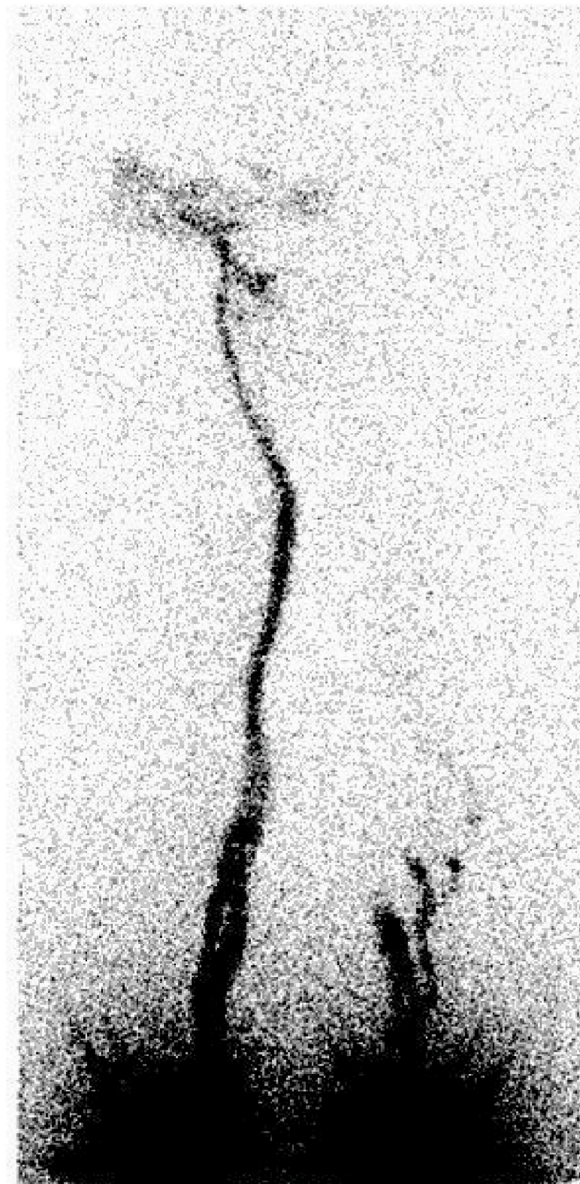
Lymphoscintigraphy showed lymphatic leakage from the scrotum to the right lateral thigh and disturbance in the lymphatic drainage on both lower extremities.
